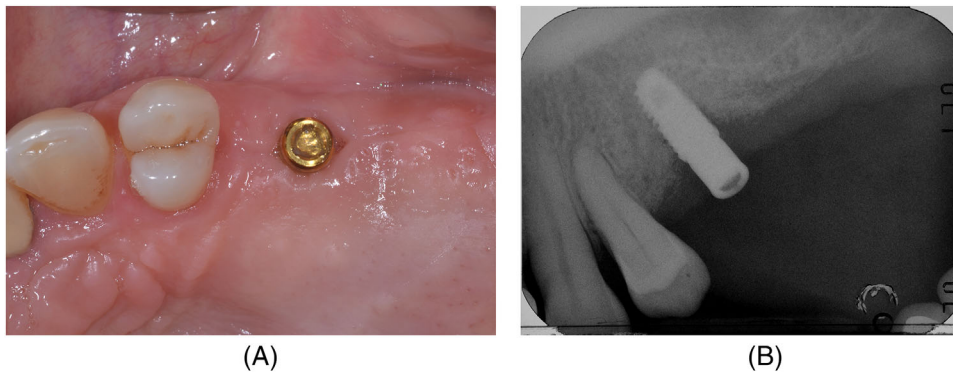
At the 6-week follow-up after abutment re-insertion, the peri-implant site was characterized by absence of erythema, bleeding on probing, swelling, and suppuration (A) and a stable radiographic bone filling (B).
